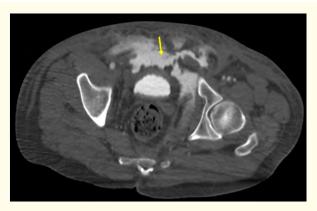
Axial CT scan showing contrast extravasation in the prevesical space.
